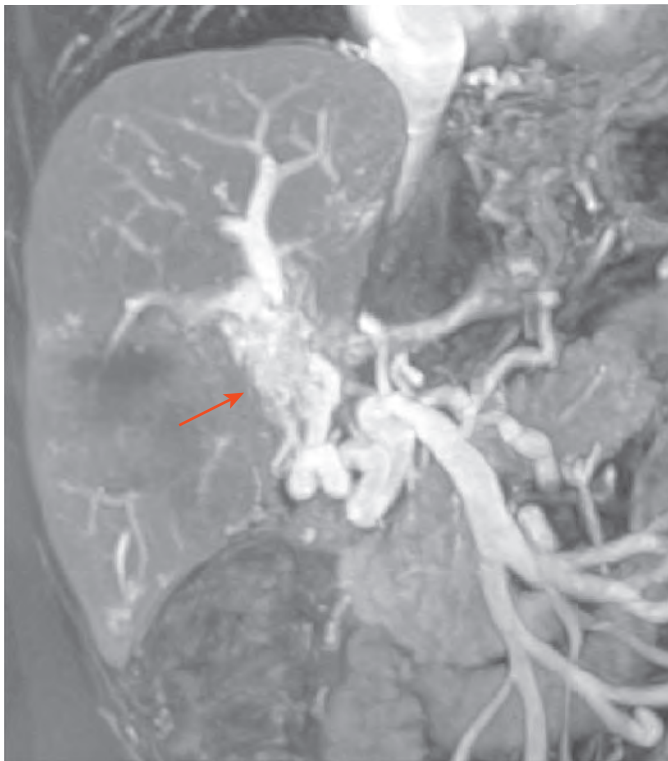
Cavernous transformation of the portal vein: MRI features. Coronal MR portogram shows multiple dilated collaterals (arrow) in the hepatoduodenal ligament and dilation of the superior mesenteric vein.
